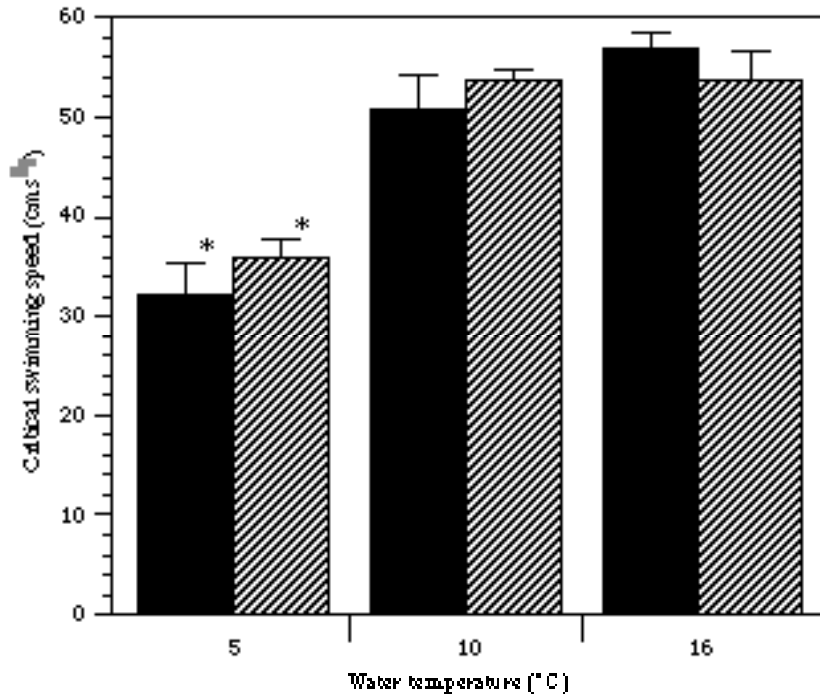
The mean ( $\pm$ S.E.)  $U_{crit}$  of six largescale suckers at 5, 10 and 16°C that were either intact (black bars) or surgically fitted with an ultrasonic flowprobe (grey bars). An asterisk denotes a significant difference between the values at 5°C and the other temperatures. No significant differences were found between the intact and surgically altered fish at any of the three temperatures.
